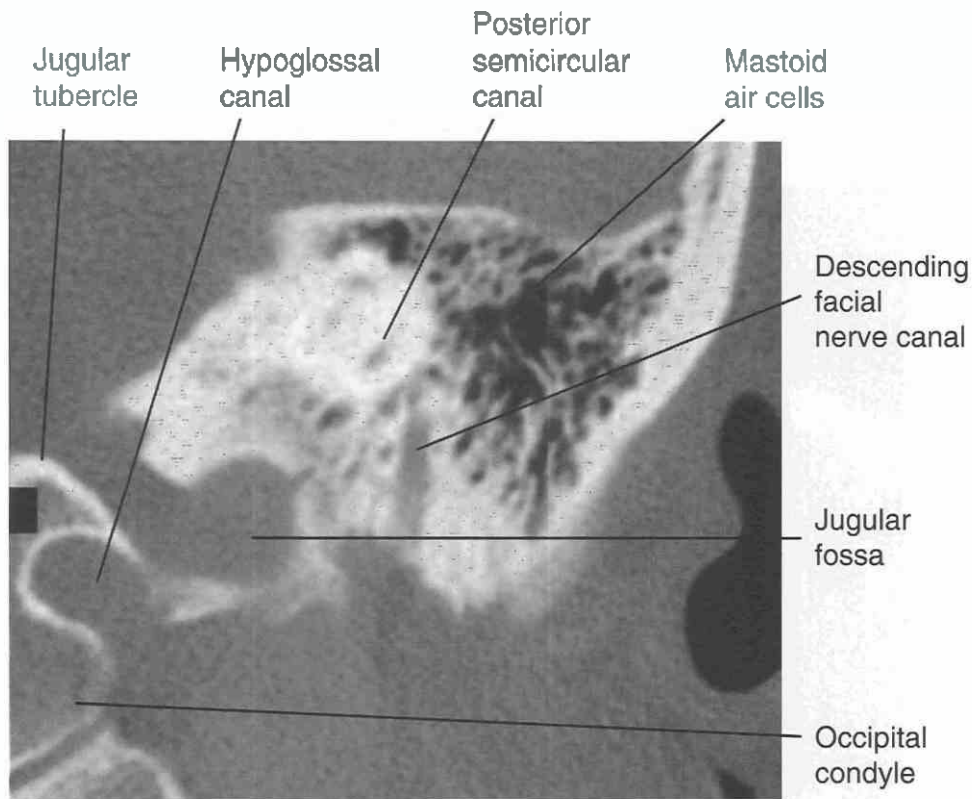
Coronal CT section. This is the most posterior section of the temporal bone. The descending facial nerve canal is seen between the mastoid air cells and the more medial jugular fossa. The jugular tubercle, hypoglossal canal, and occipital condyle all appear medial to the jugular fossa. Short segments of the posterior semicircular canal are seen.
